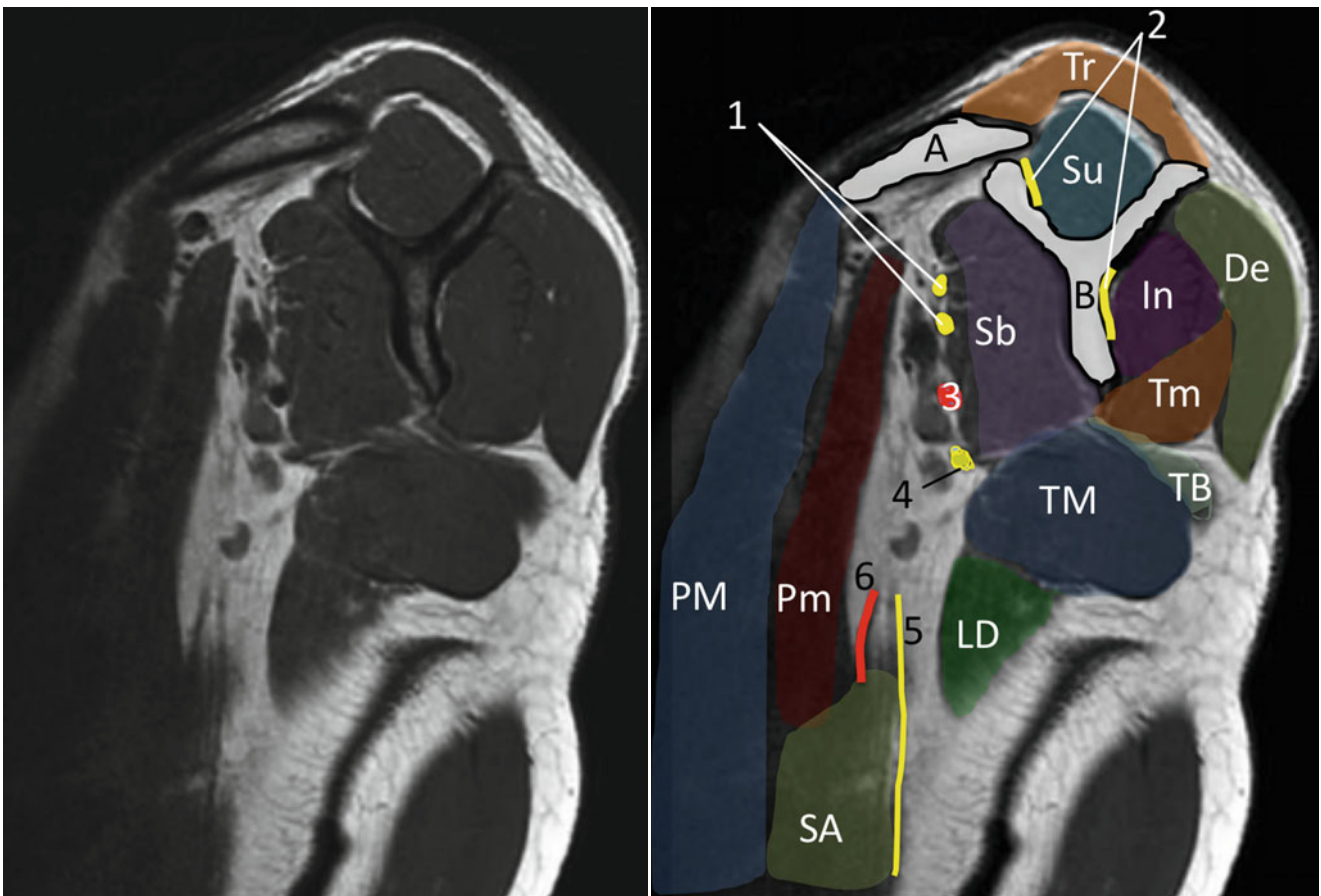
Sagittal MRI image of the scapular structures. *A* clavicle, *B* scapula, *De* deltoid muscle, *In* infraspinatus muscle, *LD* latissimus dorsi muscle, *PM* pectoralis major muscle, *Pm* pectoralis minor muscle, *Sb* subscapularis muscle, *Su* suprascapular muscle, *TM* teres major
